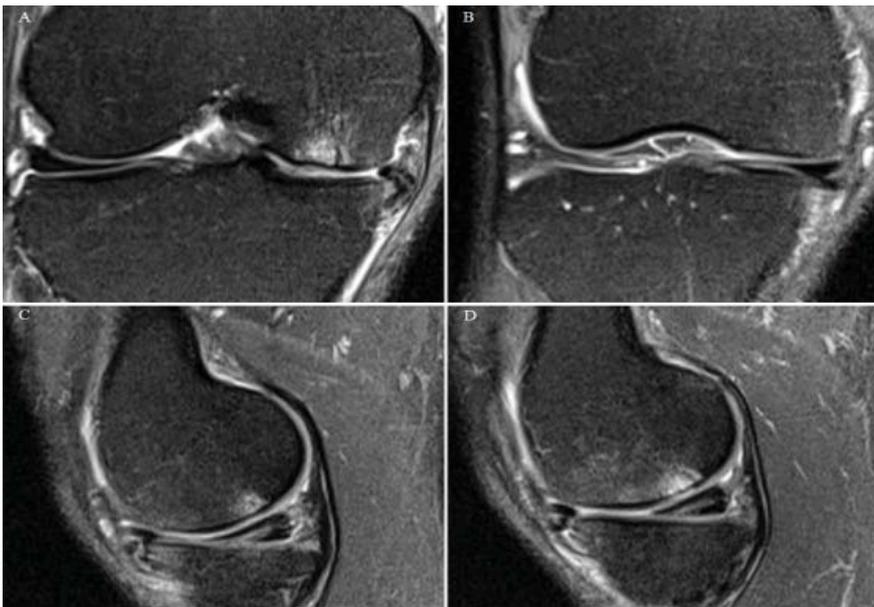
The MRI images were reviewed again after arthroscopy. (A,B) The T2-weighted coronal sections show the medial meniscus tear displaced inferiorly and medially into the medial tibial gutter. There is an area of marrow edema at the medial femoral condyle corresponding to the area of denuded cartilage seen arthroscopically. (C,D) The sagittal sections show the posterior horn tear with a horizontal cleavage line anterior to it corresponding to the flap tear displaced inferiorly beneath itself.
